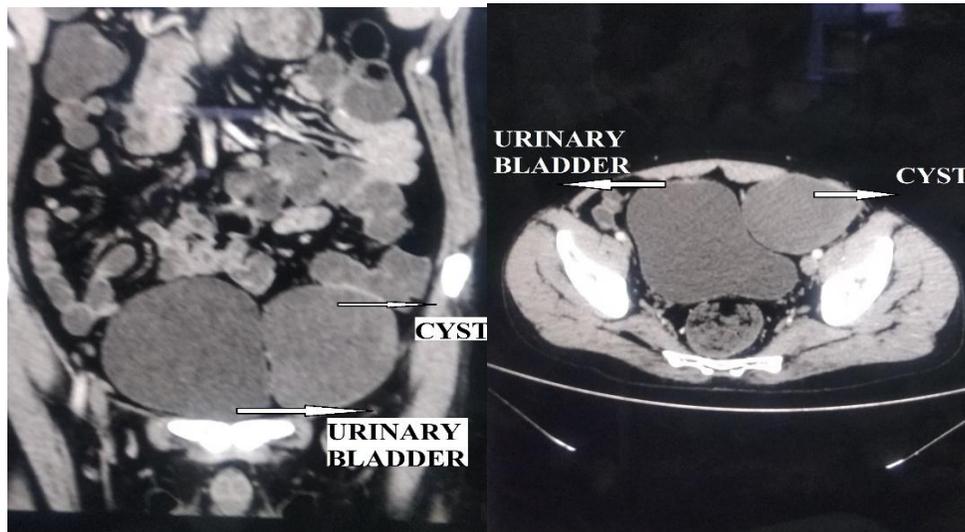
CT image of cyst (Coronal and axial view)
